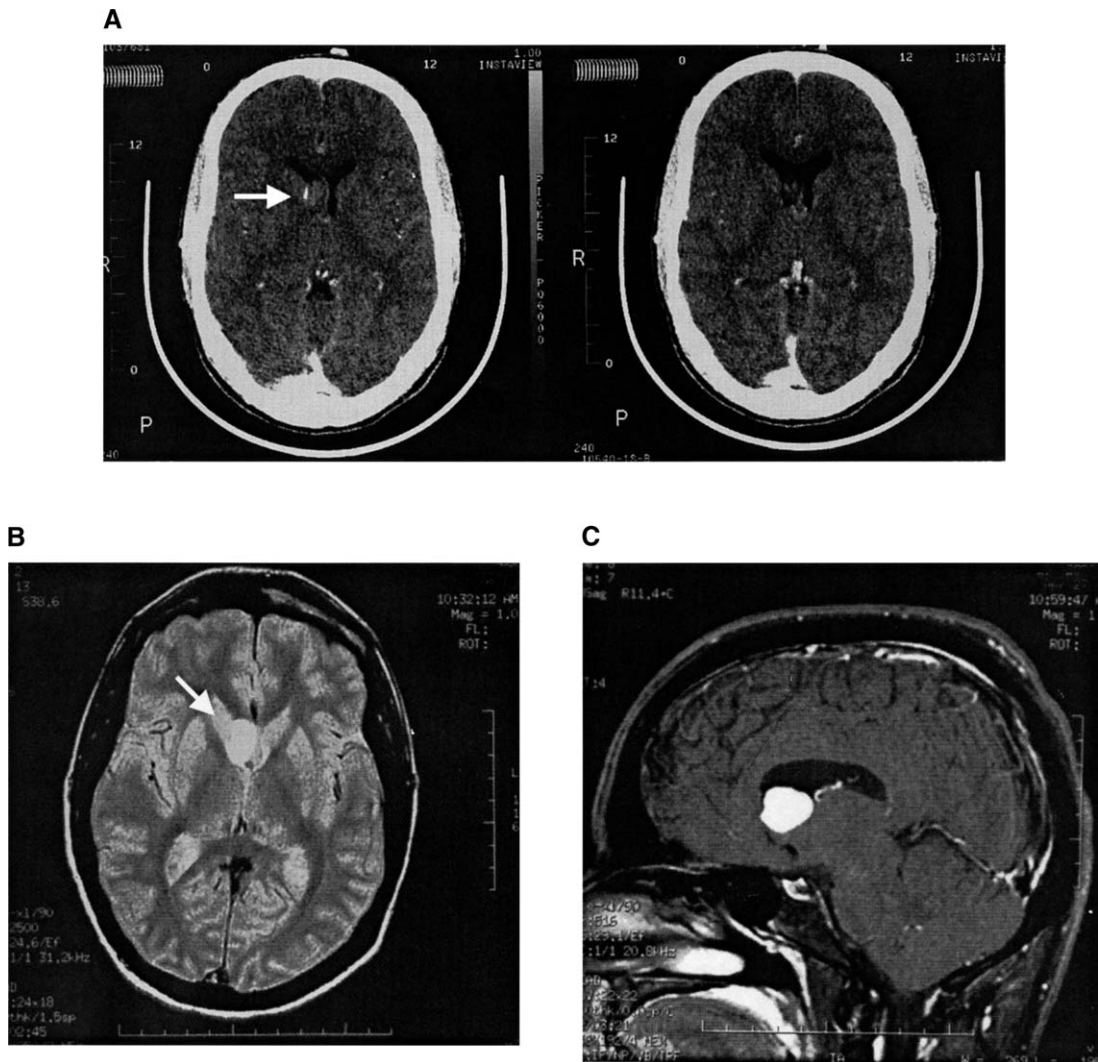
Subependymoma. (A) A nonenhancing lesion in the right frontal horn of the lateral ventricle. (B) The mass has significant hyperintensity on gradient echo MRI. (C) An unusual appearance of intense homogeneous enhancement after administration of intravenous gadolinium.
